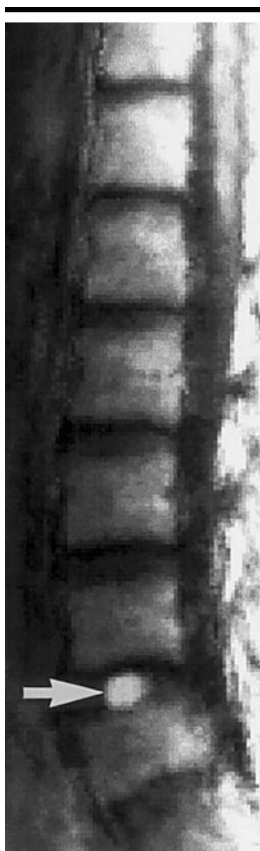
Spatial distribution of the average of 14 lesions after spatial normalization with the template. The lesions were originally placed within the L4-L5 disk of each subject's images and were subsequently spatially normalized according to the elastic warping transformation determined by the computer algorithm. The average spatially normalized MR image is shown in the background for reference. Tightness of this spatial distribution (arrow) is critical in statistical methods that are used to seek associations between lesion location and clinical symptoms, since those methods assume a perfect overlap of lesions that are in anatomically corresponding regions.
